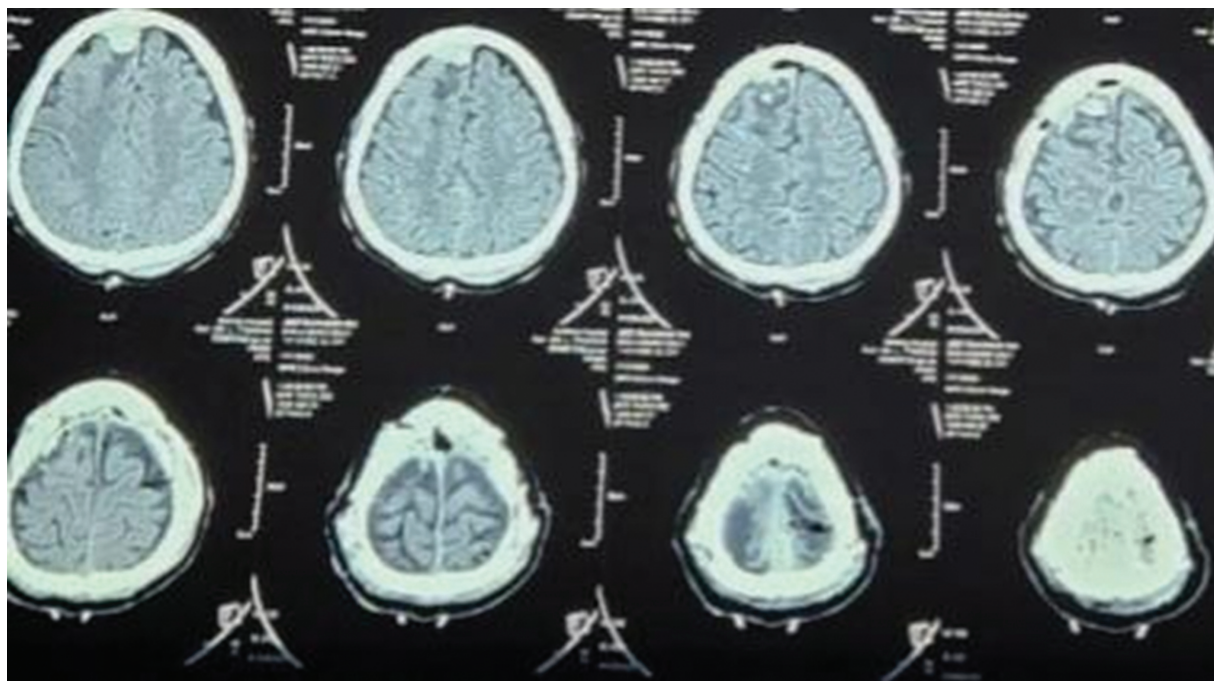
Postoperative computed tomography showing complete evacuation of vertex epidural hematoma.
